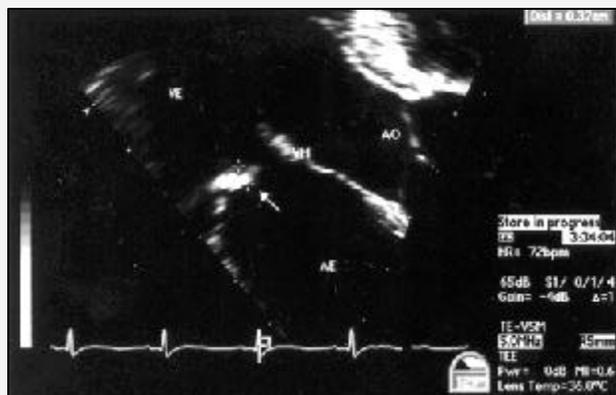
Transesophageal echocardiogram showing thickening of the mitral valve and absence of vegetation.
